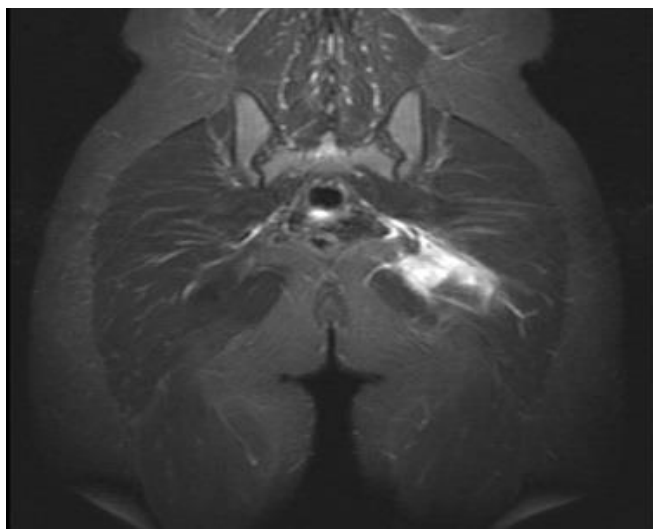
Magnetic resonance image of the patient's grade II obturator internus strain.
